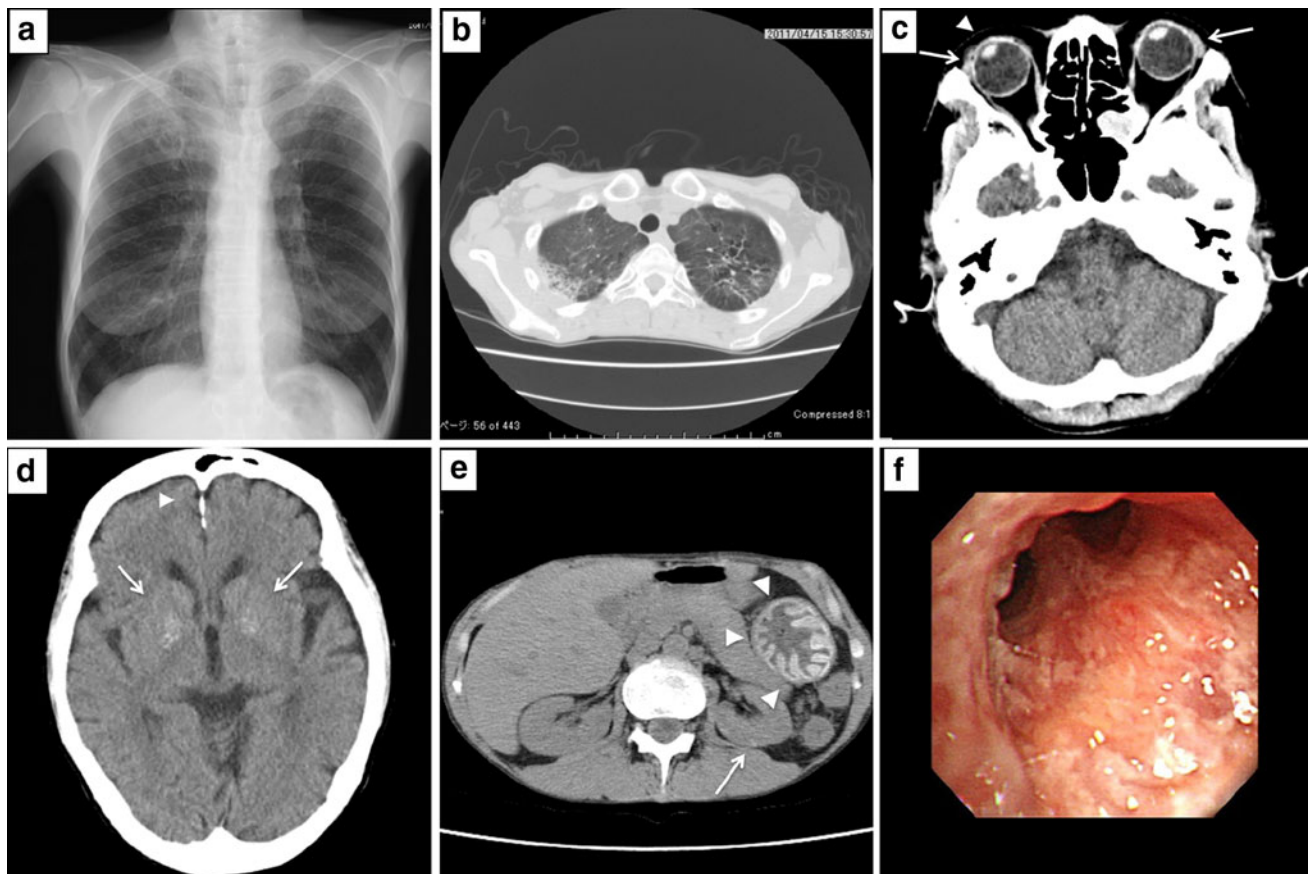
a Chest roentgenogram revealing a tumor lesion in the right upper lung and slight diffuse shadows in the bilateral upper lungs. b Computed tomography revealed diffuse ground-glass opacities in the bilateral upper lungs and a tumor-like lesion with a cavity in the right upper lung. c, d, e Computed tomography revealed multiple
